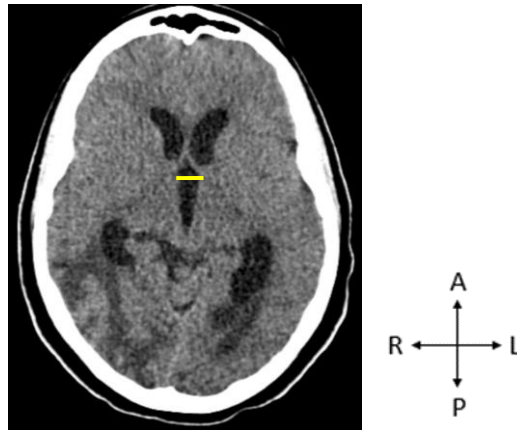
A CT scan of the brain in the axial view, indicating the third ventricle width. Image taken from the GSH PACS by (20 October 2023). A - Anterior, R - Right, P - Posterior, L - Left.
